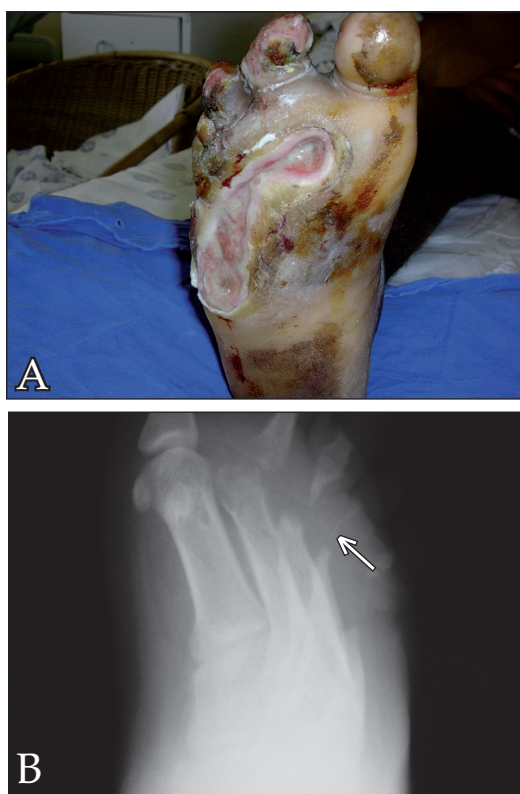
A: Deep ulcers of the right foot. B: Radiograph showing extensive destruction of the metatarsophalangeal joints (arrow).
